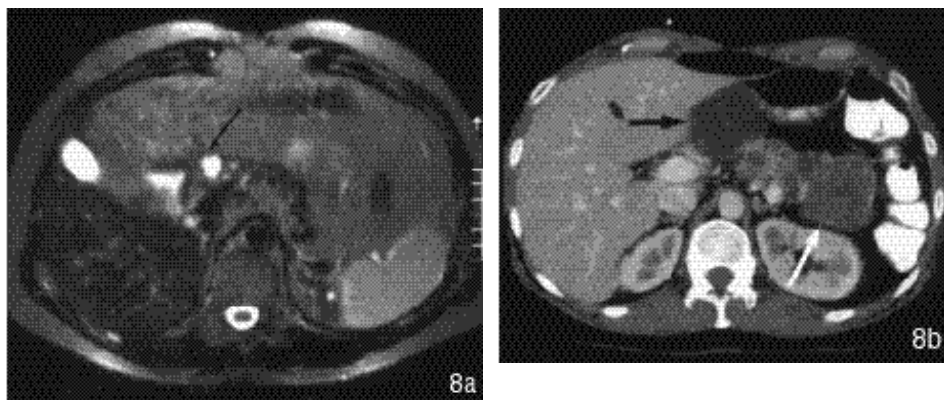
Pancreatic lesions in VHL disease. a T2-weighted image (TR/TE = 2323/100) shows a small pancreatic cyst (arrow) in a 40-year old male with renal cell carcinoma (not shown). b CT in a 31 years old female with multiple pancreatic cystic lesions in corpus and tail of the pancreas with soft tissue parts, most probably serous cystadenoma (white arrow). On MRI one year before, the lesions had high signal intensity on the T2-weighted images. Despite some mass effect these lesions do not require resection. Moreover, she developed a pseudocystic mass (black arrow) due to a ventriculoperitoneal catheter in this region, inserted after surgery of a cerebellar haemangioblastoma.
